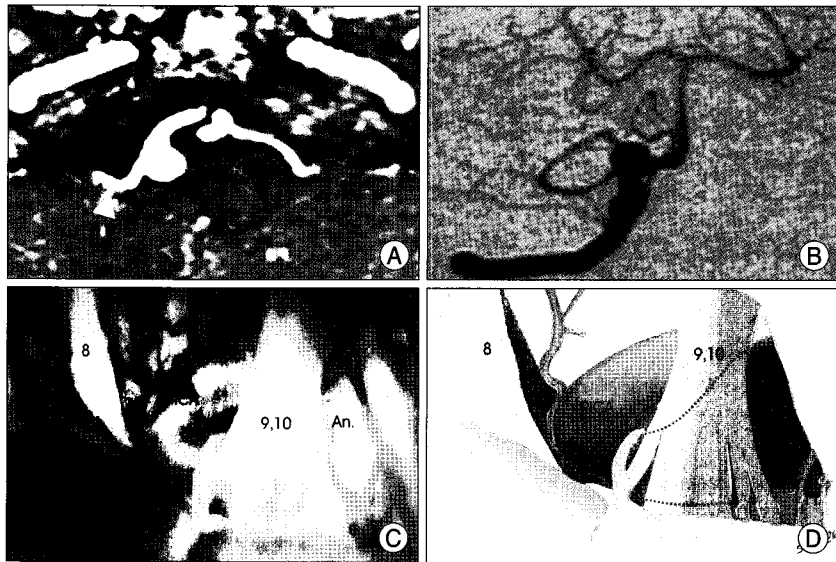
A : Posterior inferior cerebellar artery (PICA) (arrow head) and aneurysm (arrow) contact on brain stem on 3-dimensional short range magnetic resonance imaging. B : Right vertebral angiogram shows fusiform aneurysm at vertebral artery (VA)-PICA junction. C and D : On operative finding, the compression on root exit zone is mainly induced by PICA and partially by aneurysm. An : aneurysm.
